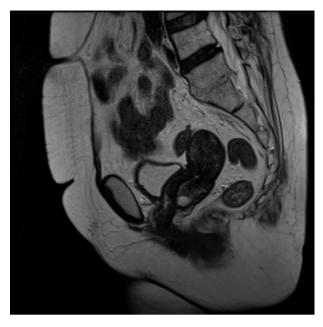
(A) 1.7×1.5 -cm cervical mass with a homogeneous intensity on T1-weighted images and a heterogeneous intensity on T2-weighted images on posterior cervix.
